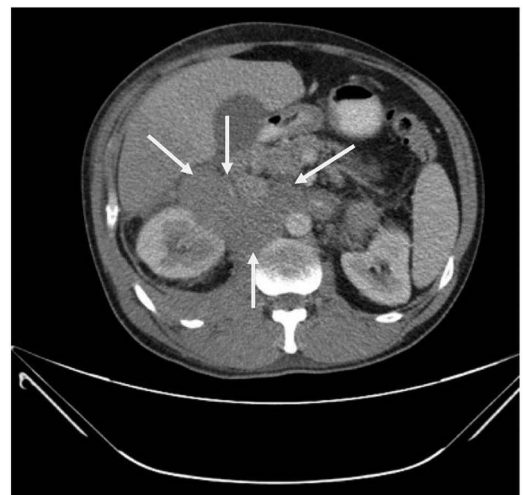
CT of the abdomen demonstrating a 11 cm solid mass arising from the left adrenal gland.
